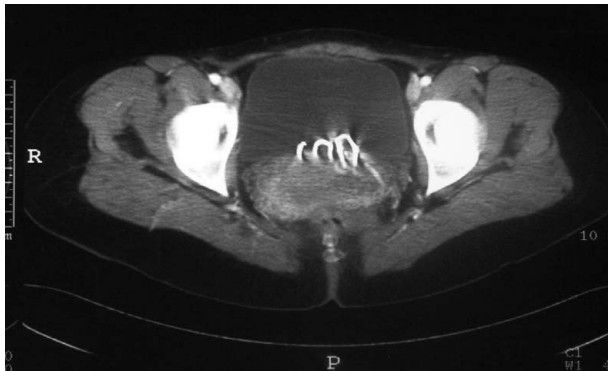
Computed tomography shows perforation of the uterus and migration of the intrauterine device into the bladder.
